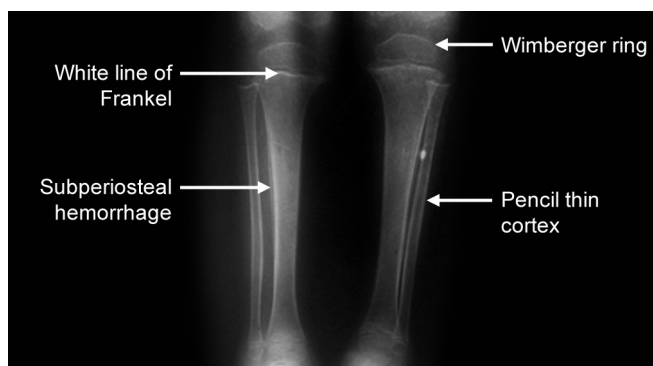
X-ray showing characteristic signs of scurvy.
